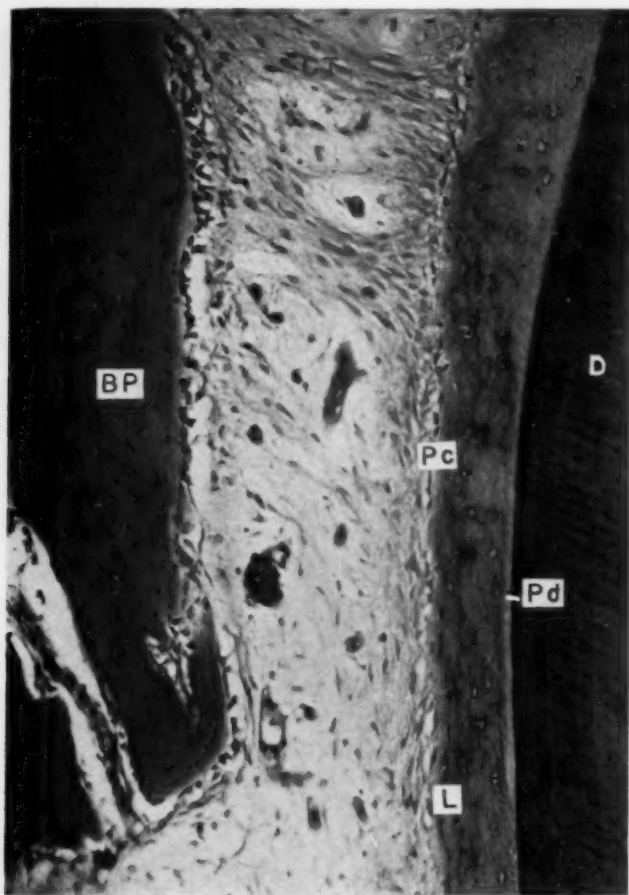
Higher magnification of area of Fig. 4. Note resemblance to normal paradentium. Calcified dentine (*D*); predentine (*Pd*); bonelike tissue (*BP*), resembling cementum. Un-calcified surface on bonelike tissue resembling precementum (*Pc*). Connective tissue (*CT*) resembles periodontal membrane. Bony process (*BP*) in papillary area.
